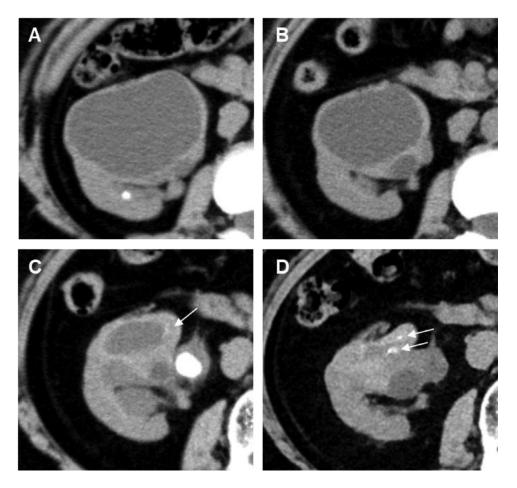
Long-term longitudinal changes of MEST of the right kidney. Serial noncontrasted CT images obtained 13 years ago (A), 10 years ago (B), 6 years ago (C), and just before the right nephrectomy (D). The tumor was approximately 7 cm in diameter 13 years ago, after which the overall size of the tumor gradually decreased. With time, the largest cystic structure showed gradual shrinkage and the cystic wall continued to thicken, changing into a lesion with predominantly solid components. Small calcifications (arrows) were apparent within the mass on CT obtained 6 years previously.
